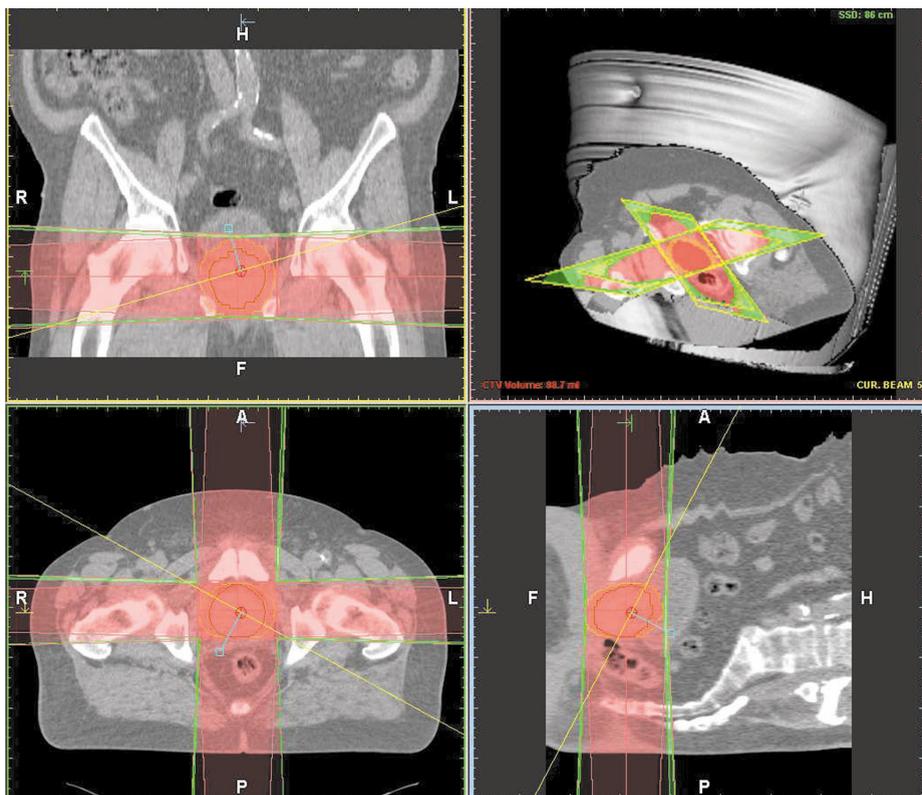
Evaluation of the four-field box technique making use of the oblique cut visualisation tools of EXOMIO. Coronal plane view [top left], sagittal plane view [bottom right], CT slice [bottom left] and OEV with oblique cut, field geometries and 3D PTV [top right]. The yellow line in the three major planes indicates the position of the oblique plane viewed in the 3D OEV window
